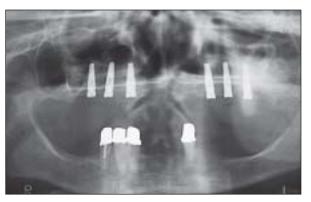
Panoramic radiograph of implants placed in augmented bone in the maxillary posterior region.
